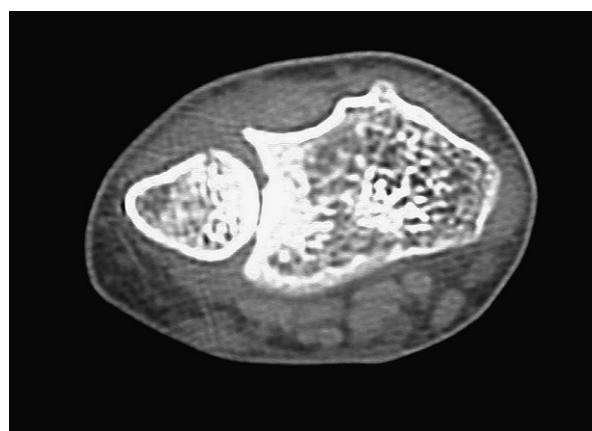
Twelve-month postoperative CT scan after osteotomy and bone graft of the dorsal lip of sigmoid notch.
